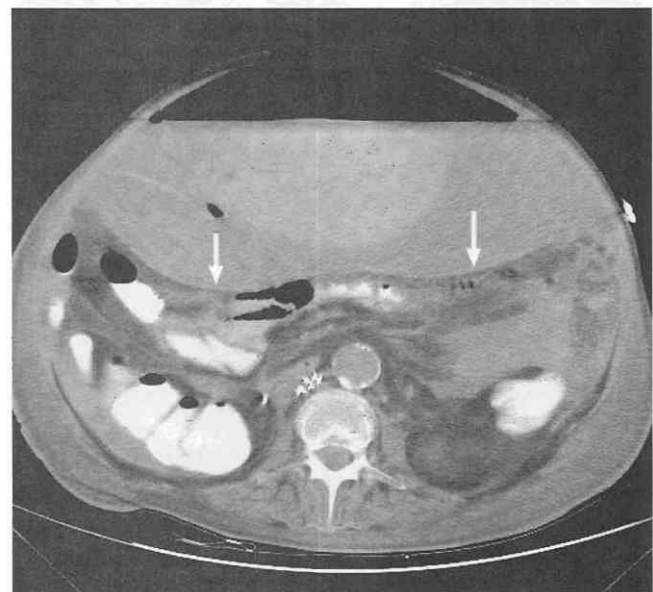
Large collection of blood in the anterior peritoneum. CT scan shows a large fluid collection containing internal clot. Arrows define the posterior wall.
